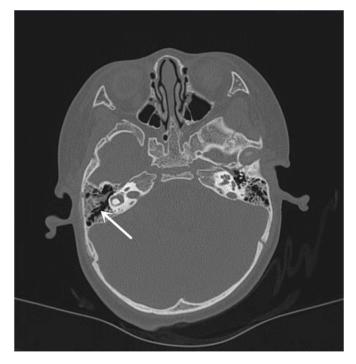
Computed tomography image of the patient after the injury. The arrow refers to the focus.
